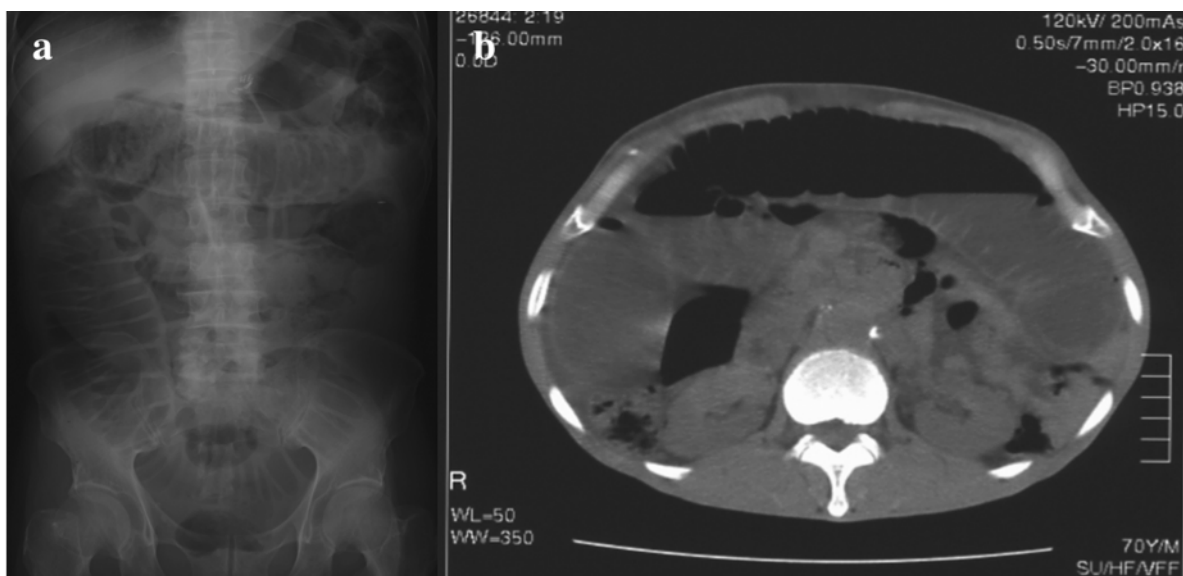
An abdominal X-ray examination revealed the apparently dilated loops of the small intestine. (a). Abdominal computed tomography (CT) also revealed the dilated small intestine including gas and fluid (b).
